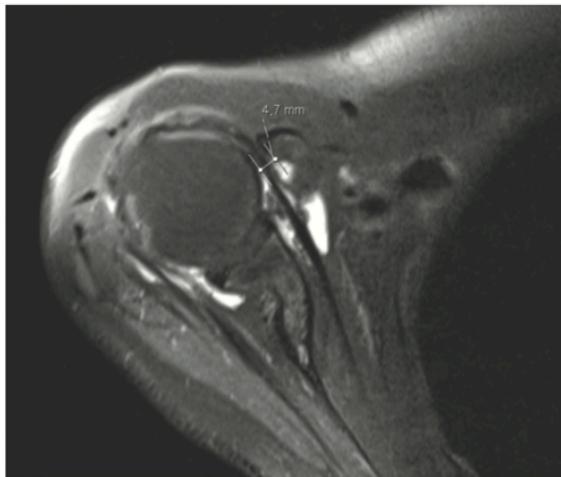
Coracoid overlap measurement using T1-weighted MRI transversal cuts.
